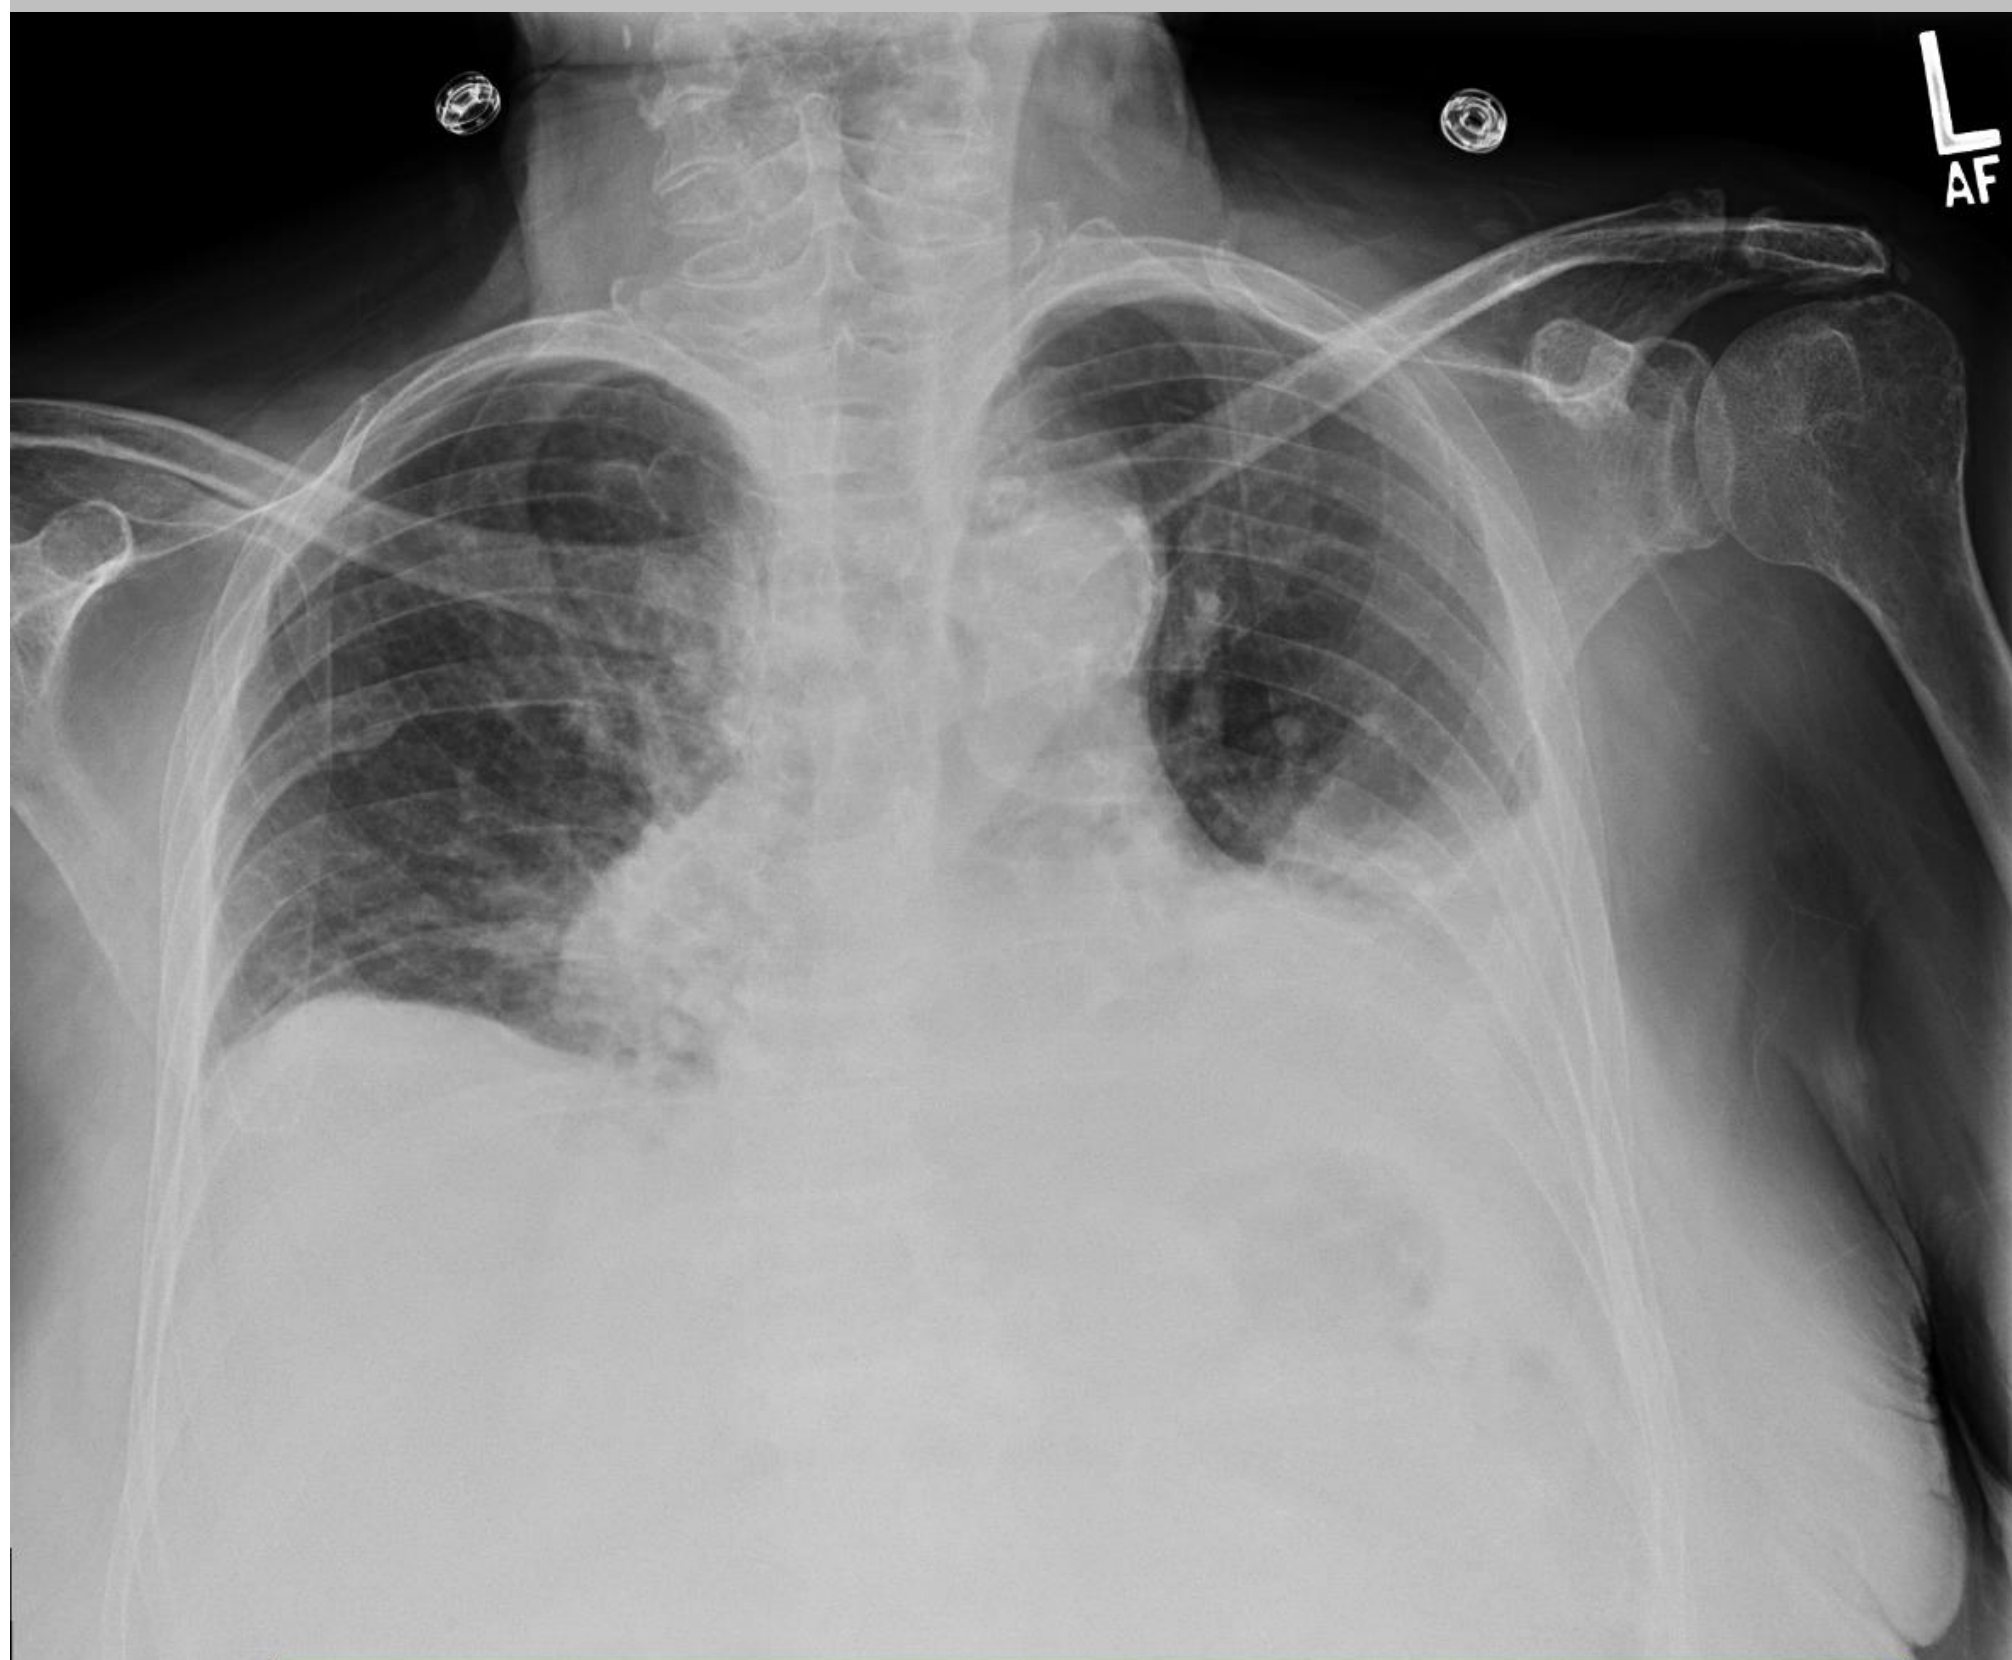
Initial chest x-ray revealing pleural effusion, further characterized in CT chest seen in Figure 2.
